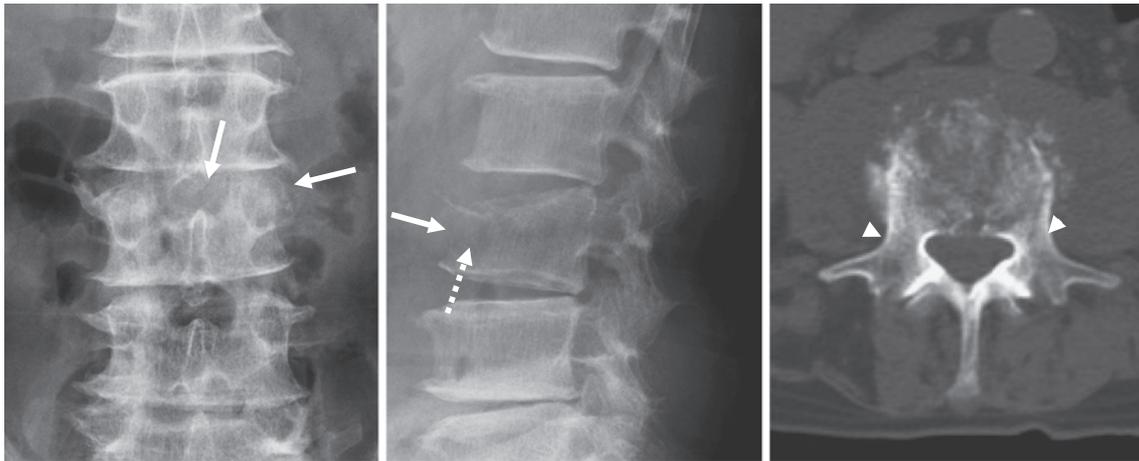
Radiographic imaging of a 66-year-old man with third lumbar vertebra metastasis of lung cancer. Radiographs show the disappearance of the anterior, left lateral, and cranial cortices (arrows) and increased radiolucency of the central area in the vertebral body (dashed arrow). CT shows the extensive destruction of the vertebral body, but no destruction of the pedicles (arrowheads).
